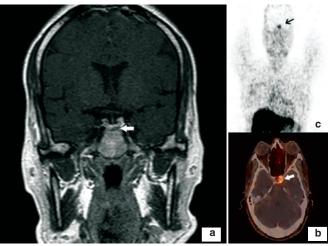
a: MRI brain showing left-sided pituitary micro-adenoma; b and c: Ga-68-DOTANOC scans showing increased radioisotope uptake in the area corresponding to the adenoma on MRI.
